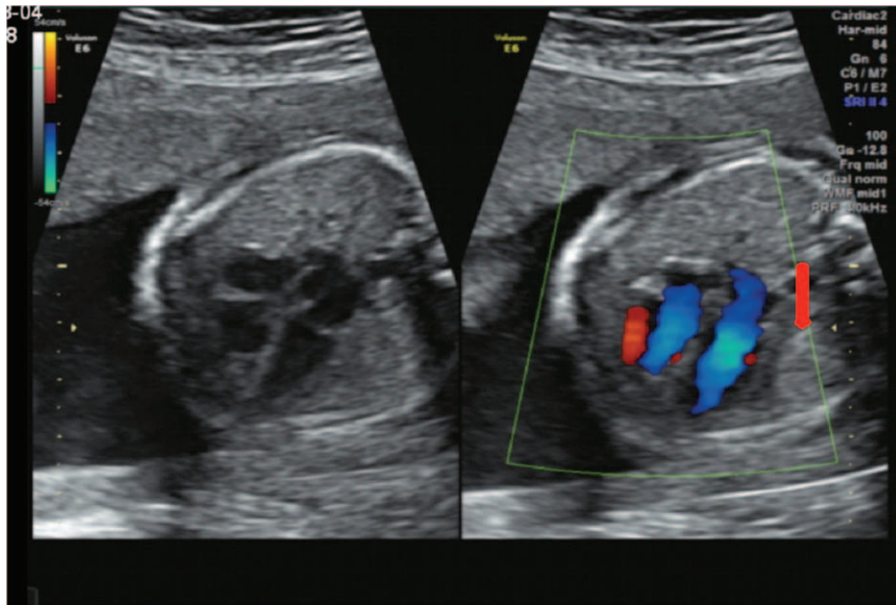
Ultrasonography at 28 weeks of gestational age showed a 0.8×1 cm relatively well-defined oval-shaped mass in the left hemithorax.
